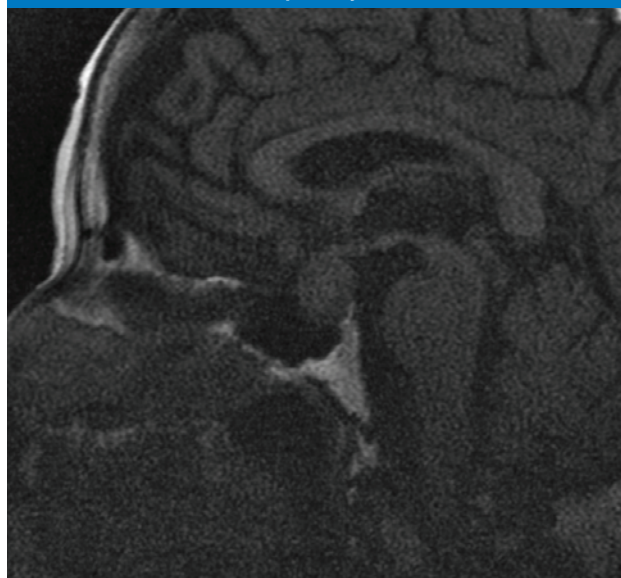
MRI, sagittal T1 FLAIR without contrast depicting a pituitary macroadenoma (red arrow).
